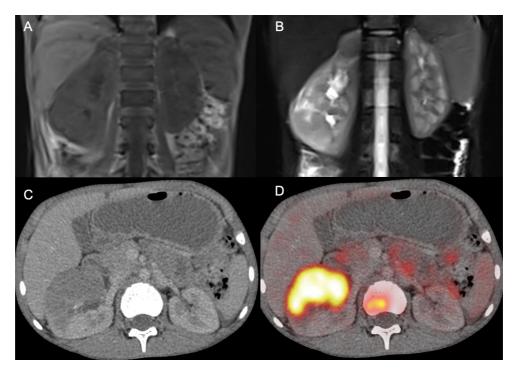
(A) Coronal T1, (B) STIR, (C) Axial CECT and (D) PET-CT images showing lymphomatous involvement of the right kidney, and lumbar vertebral bodies.
